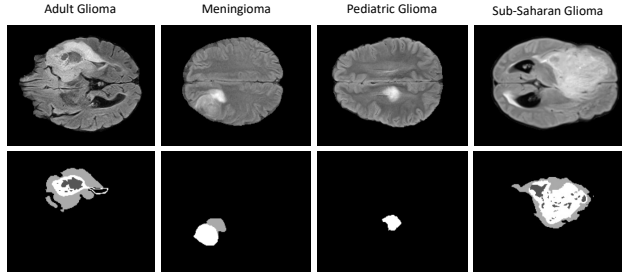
Four selected brain tumor domains. The top row represents samples from the T2-FLAIR MRI modality and the bottom one is the ground-truth. In the ground-truth images, white pixels are part of the enhancing tumor, light grey pixels represent an edema, and dark grey pixels are necrotic/non enhancing cells. However, we will only focus on the ground-truth complete extension of the tumor.
